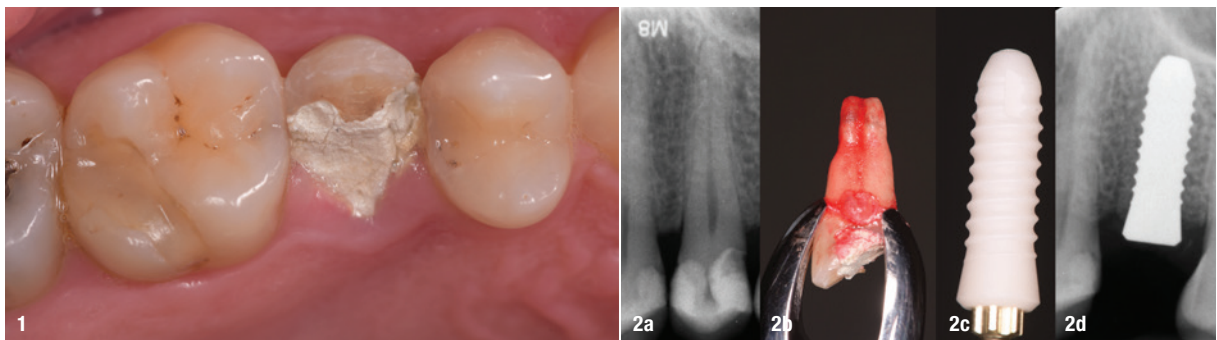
Occlusal image of the coronal fracture of the partially medicated tooth to soothe the thermal sensitivity caused by uncovering of the pulp chamber. Figs. 2a–d: Initial radiographic image showing the close proximity to the floor of the maxillary sinus in addition to the viability of the tooth and the absence of periradicular infection (a). Extracted root (b). CERALOG Hexalobe implant (c). The result of implant placement with respect to the sinus floor and the osseous and interradicular relationship (d).
